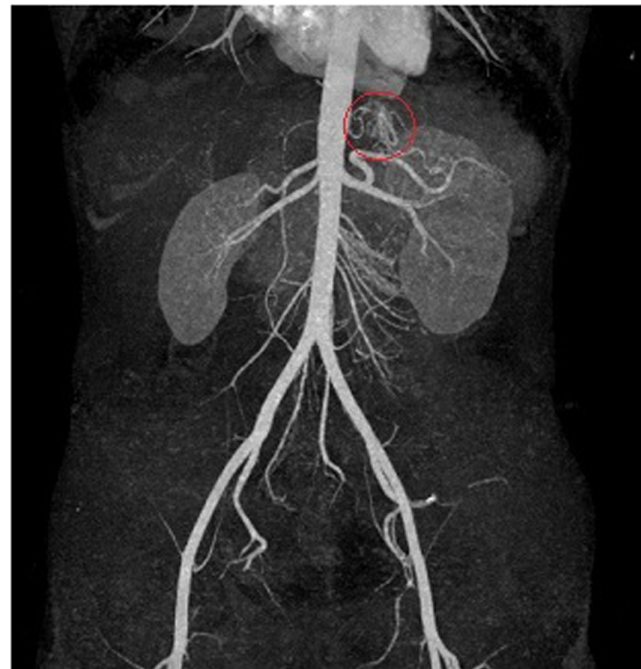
Computed tomography (CT) angiography. In CT angiography, vascular conglomerate at the gastric fundus.
